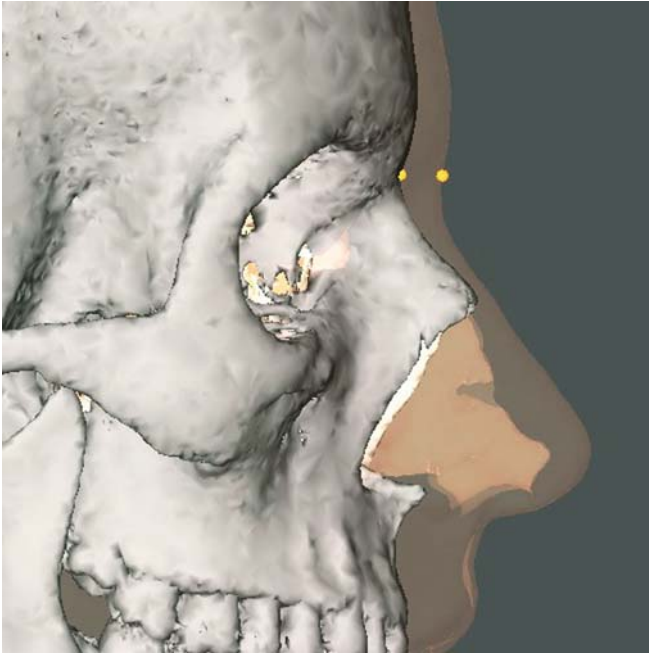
Soft tissue nasion. Note that the 3-D cephalometric soft tissue nasion landmark is located on the soft tissues and is therefore not identical to the anthropometric soft nasion landmark, which is the same as the bony Nasion landmark. (3-D CT, transparent soft tissues, patient K.C.)
